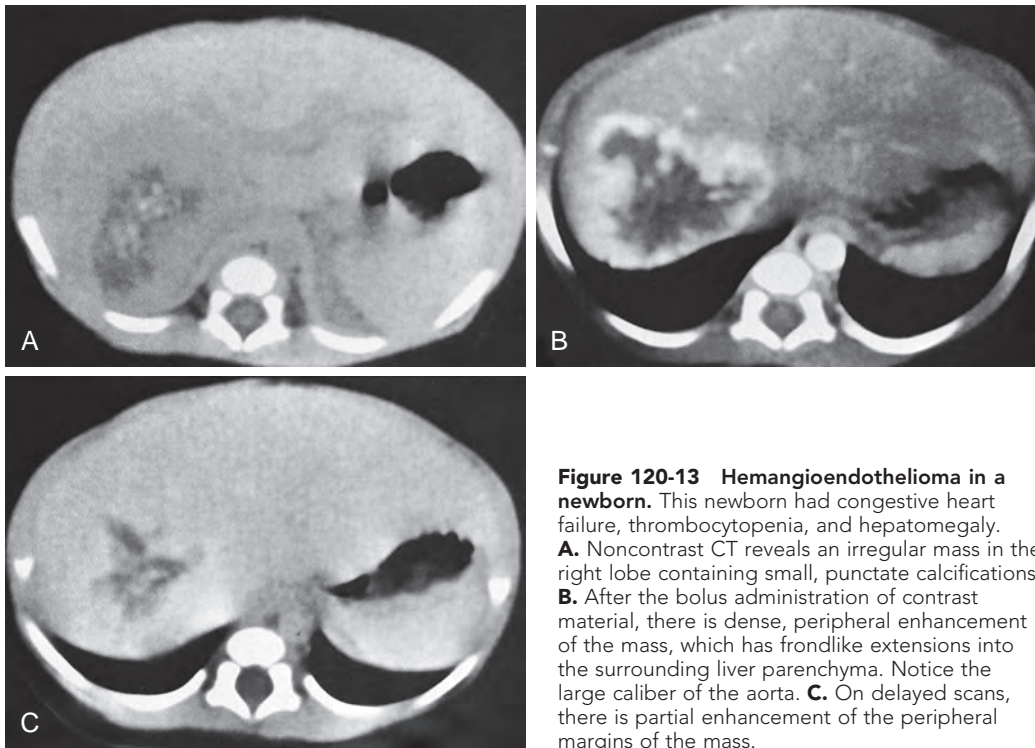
Hemangioendothelioma in a newborn. This newborn had congestive heart failure, thrombocytopenia, and hepatomegaly. A. Noncontrast CT reveals an irregular mass in the right lobe containing small, punctate calcifications. B. After the bolus administration of contrast material, there is dense, peripheral enhancement of the mass, which has frondlike extensions into the surrounding liver parenchyma. Notice the large caliber of the aorta. C. On delayed scans, there is partial enhancement of the peripheral margins of the mass.
